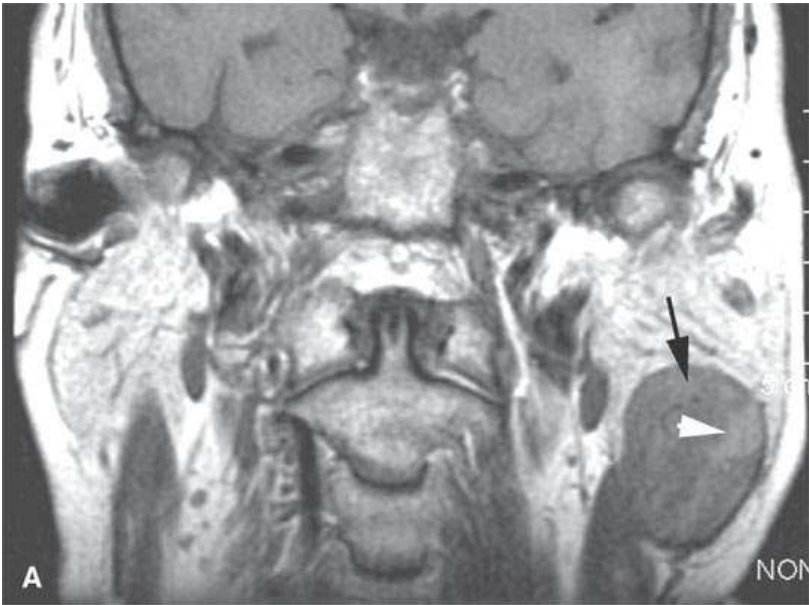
Various patients with Warthin tumors as seen on magnetic resonance imaging studies. A: Solitary mass, in the tail of the gland on T1-weighted (T1W) image (arrow) with mixed signal intensity (arrowhead). B, C: Multiple small bilateral Warthin tumors on T2-weighted (T2W) image (B) and T1W image (C). D, E: Solitary tumor in the parotid tail partially enhancing (arrows) and partially not (arrowhead) on the T1W contrast-enhanced image in (D) and solid (arrow) partially cystic (arrowhead) on the T2W image in (E).
